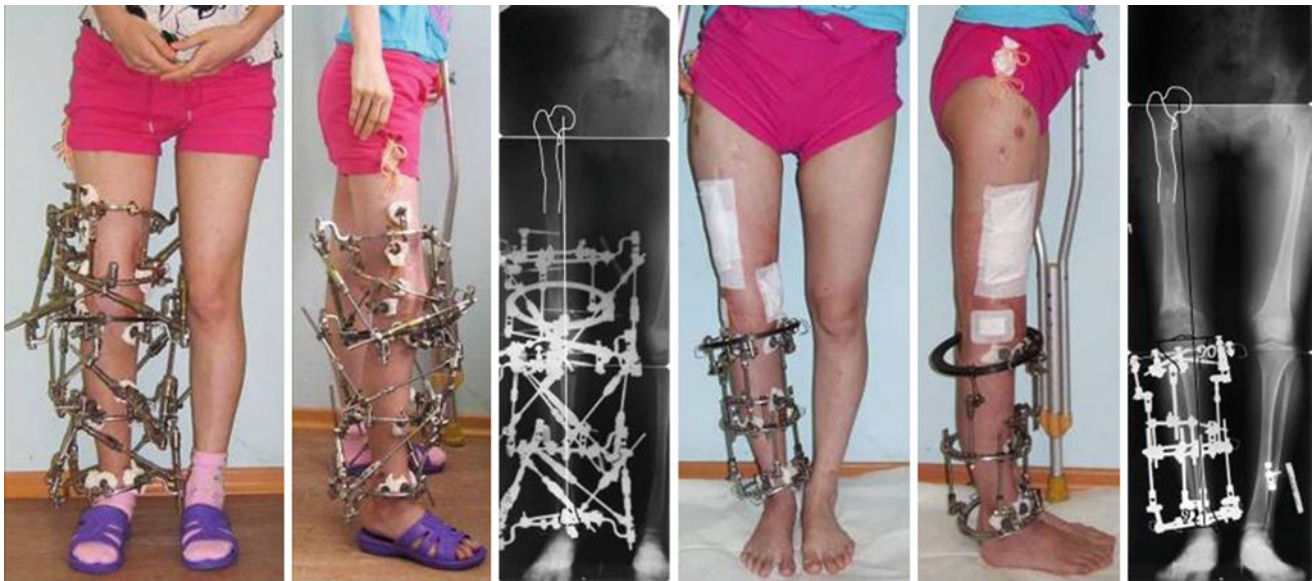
Photos and long films after lower leg deformity correction using two hexapods and secondary frame modification. Knee joint stiffness, developed at correction of the femur, is eliminated by means of an additional Ortho-SUV Frame
